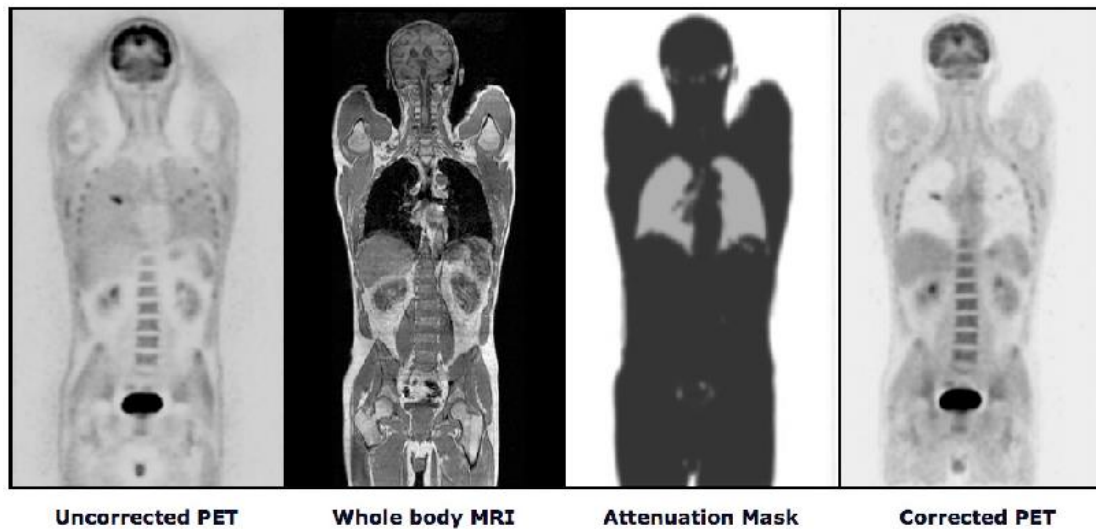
Attenuation correction for a PET system. First image of a raw PET image without attenuation correction. Next, a Whole-Body MRI image that will be used for the attenuation mask, which is the consecutive picture. Lately, by applying the attenuation mask, the corrected PET image can be calculated [101].
